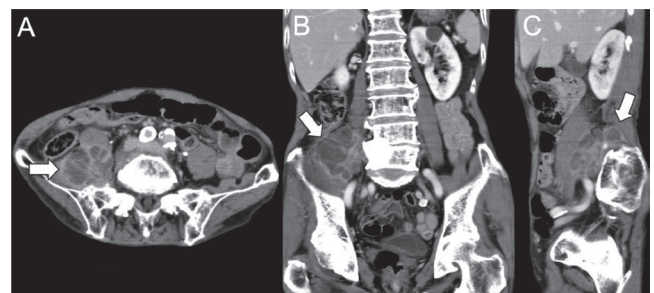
Horizontal (A), coronal (B), and sagittal (C) CT images show intramuscular multiloculated abscess in the right iliopsoas.
